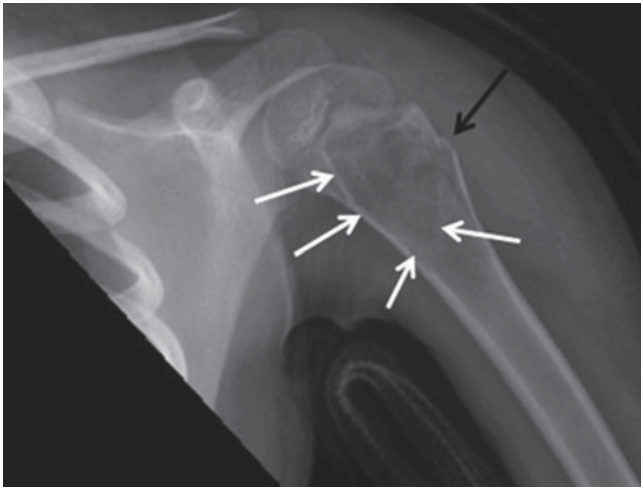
A radiograph of a 6-year-old boy who had sudden left shoulder pain while playing. The radiograph shows proximal humeral fracture (*black arrow*). Notice the simple bone cyst that affected the proximal humerus (*white arrows*)
